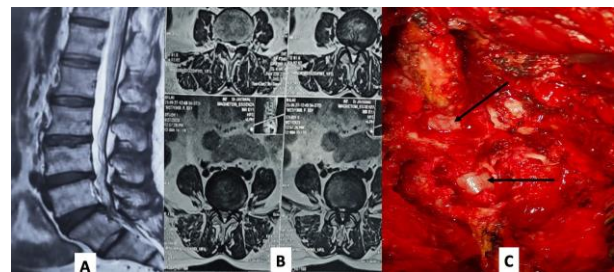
Shows preoperative MRI images of canal stenosis (A & B), intraoperative image (C) with interlaminar fenestration at two levels
